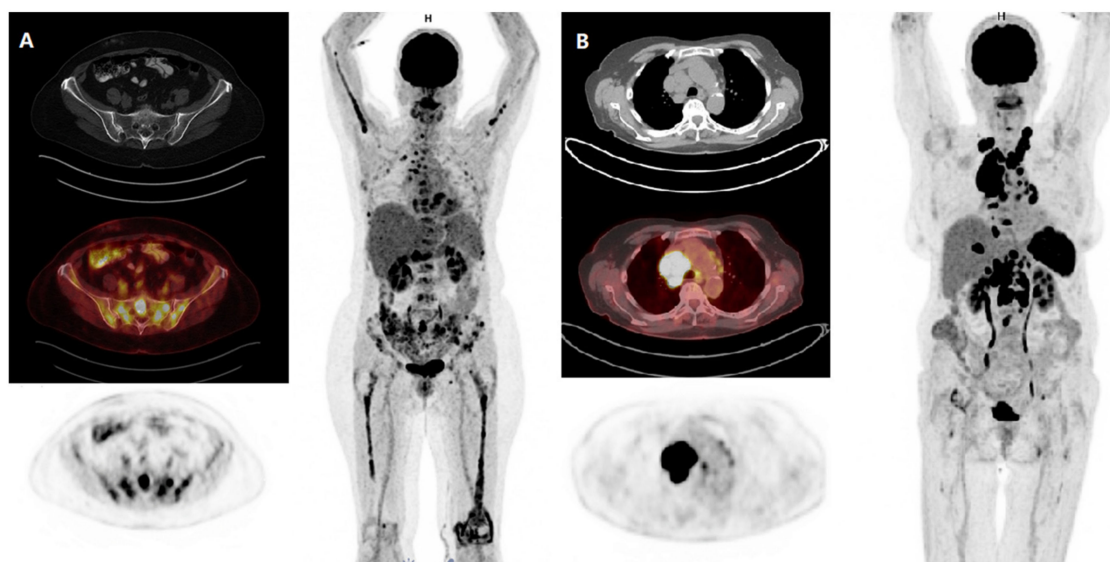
18F-FDG PET/CT in two patients with multiple myeloma. 18F-FDG PET/CT demonstrates FDG avid (A) medullary lesions (pelvis, spine, both humeri and both femurs) and (B) extramedullary manifestations (mediastinal lymph nodes) in patients with multiple myeloma. 18F-FDG, 18F-fluorodeoxyglucose; PET, positron emission tomography; CT, computed tomography.
